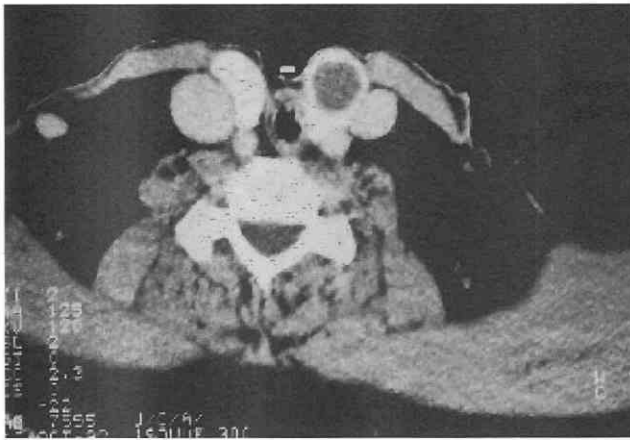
Axial postcontrast CT image shows a well-circumscribed, homogeneous, low-density mass within the left thyroid lobe. Despite its low density, the lesion is not cystic. The diagnosis was a hyperplastic thyroid nodule.
